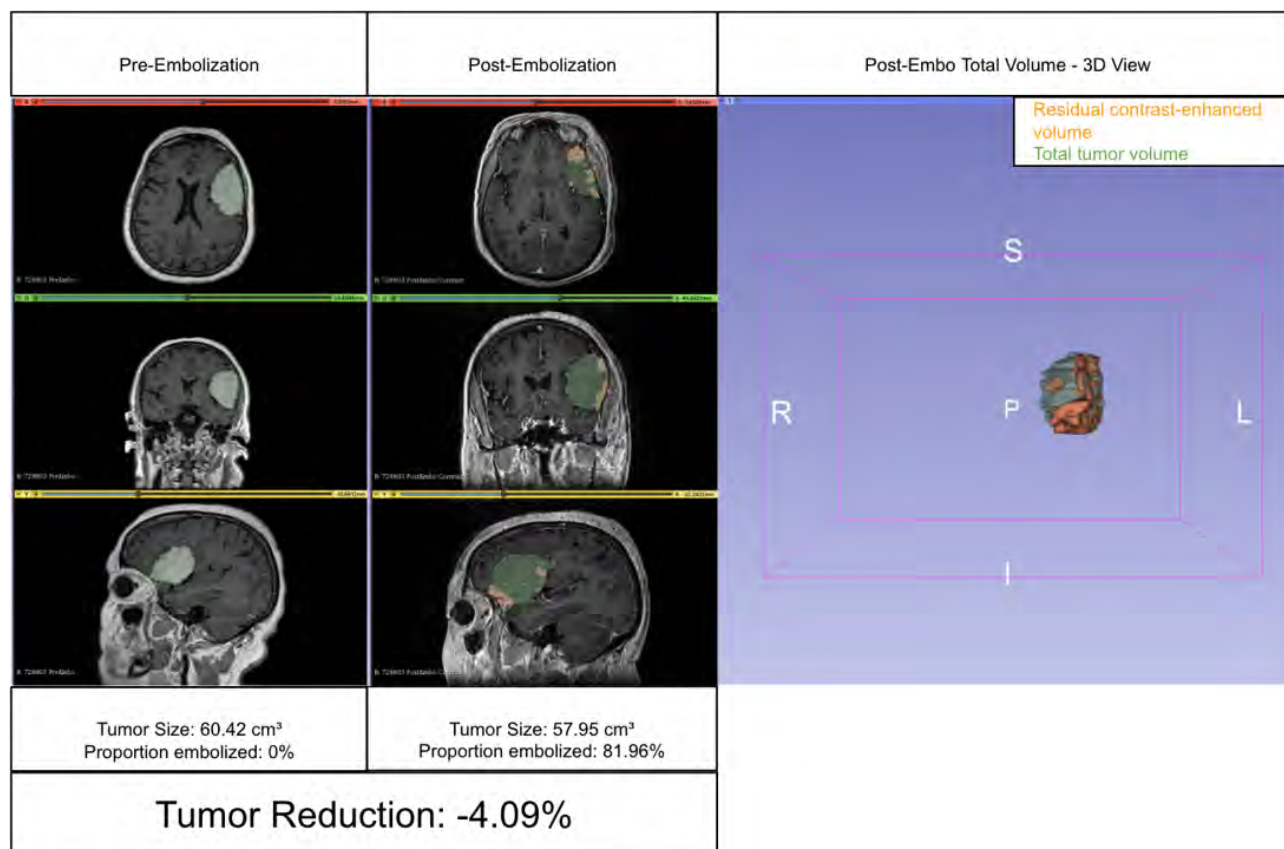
1 MRI hand-segmented analysis of patient (A) before treatment and (B) after treatment. (C) 3D rendering of residual contrast-enhanced volume within the total tumor volume after treatment embolization efficacy.
